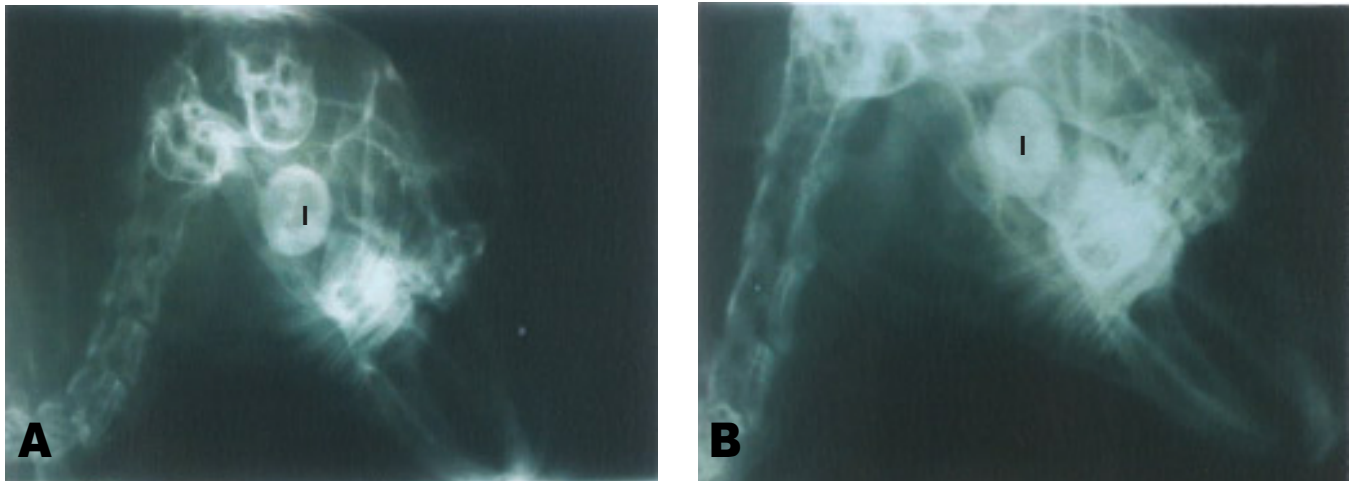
Radiographs taken 1 day (A) and 3 months (B) postoperatively show no change in radiodensity of implants (I).
